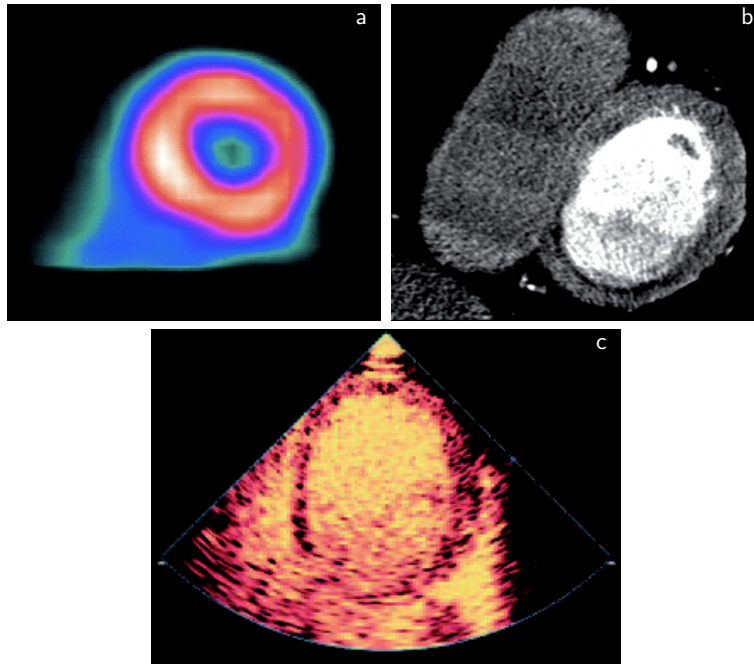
Myocardial perfusion short-axis images obtained with different modalities: SPECT (a), CT (b), MCE (c). Images respectively from Hendel *et al.* [9], Techasith *et al.* [10] and Hayat *et al.* [11].
